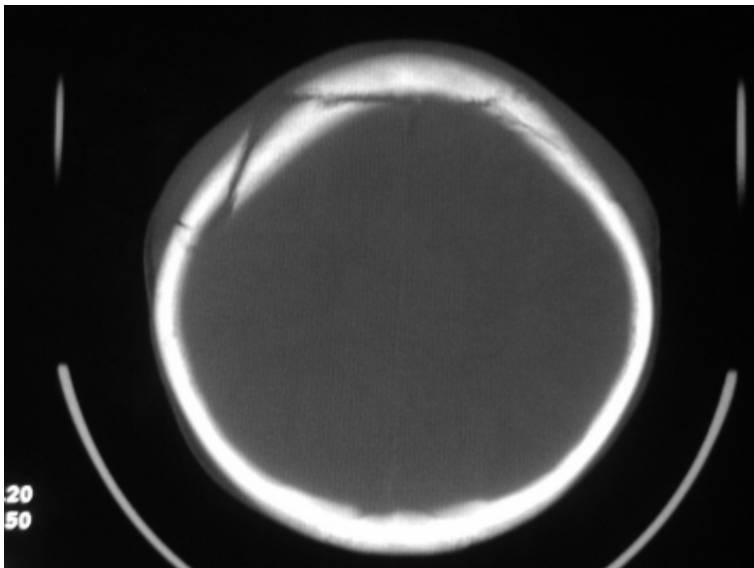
Skull fracture on bone windows on CT scan
